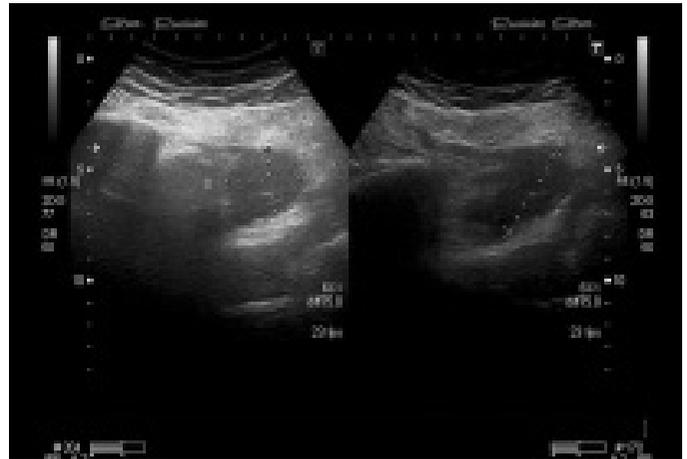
Ultrasound (US) performed at the 9th percutaneous post-treatment month demonstrates a cystic lesion (32 x 33 x 38 mm) without any anechoic (fluid) component and located posterior to the left adnexal region and anterior to the left gluteal muscles
